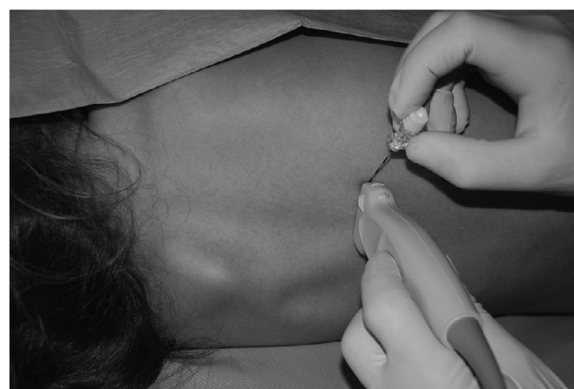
Ultrasound probe and needle position for lateral paravertebral nerve block. Reproduced with permission from Mannion S, Iohom G, Dadure C, Reisbig MD, Ganesh A (eds.) 2015. *Ultrasound-Guided Regional Anesthesia in Children*. Cambridge, UK: Cambridge University Press
